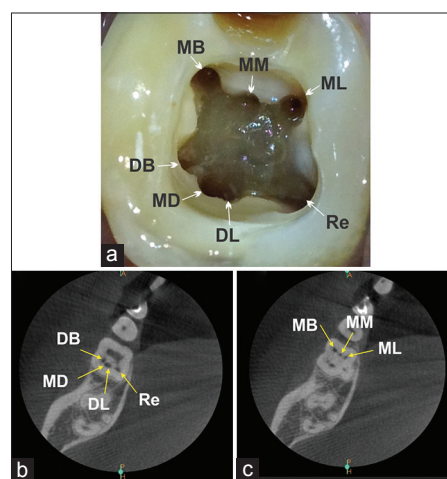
(a) Clinical view of the access cavity preparation showing seven distinct root canal orifices; mesiobuccal, mid-mesial, mesio-lingual, distobuccal, mid-distal, distolingual, and radix entomolaris. (b) Cone-beam computed tomography scan view at the coronal third showing four distinct root canals; distobuccal, mid-distal, disto-lingual and radix entomolaris. (c) Cone-beam computed tomography scan view at the middle third showing three distinct root canals; mesiobuccal, mid-mesial and mesiolingual
